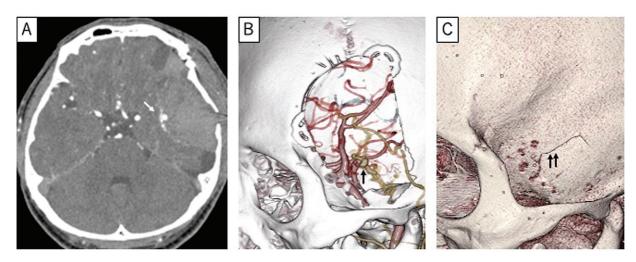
(A) Contrast-enhanced computed tomography (CT) performed 8 days after the initial surgery confirmed the presence of the aneurysm of the middle meningeal artery located at the deepest part of the hematoma (white arrow). Three-dimensional CT angiography showed the (B) middle meningeal artery aneurysm (black arrow) corresponding to the (C) temporal bone fracture (double arrow) during head injury.
